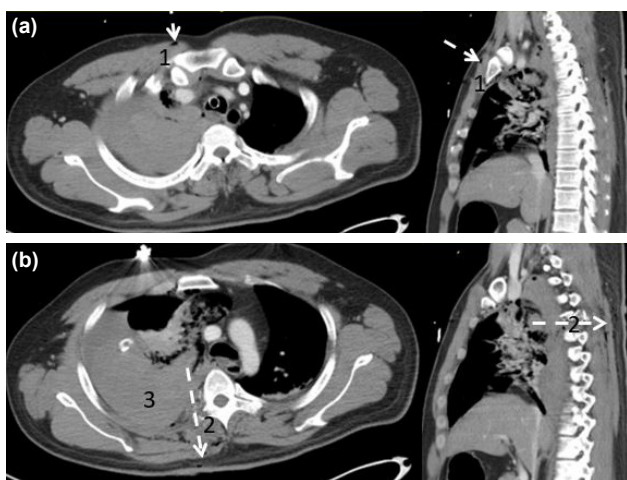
Computed tomography scan of the chest. The trajectory is represented by the white arrow. (a) Subcutaneous emphysema near the right first intercostal space and sternum. (b) Fracture of the right fourth transverse process and the right hemothorax.
